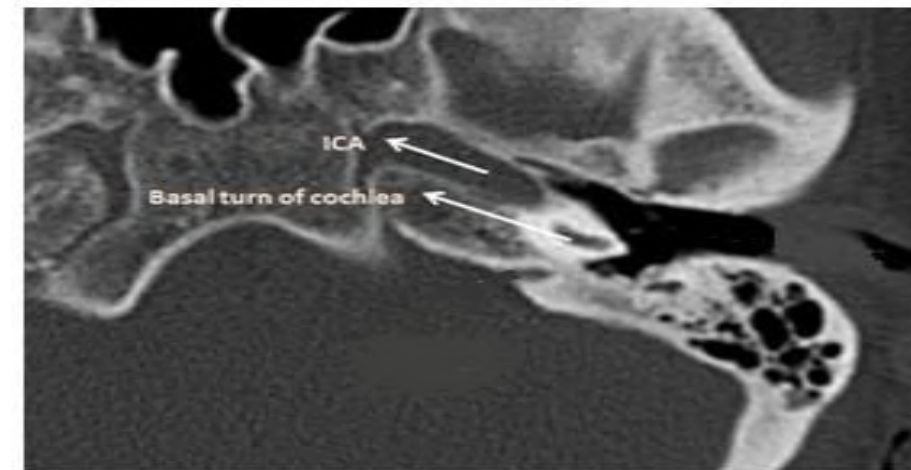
Axial CT scan of the petrous bone showing alignment between the basal turn of the cochlea and the horizontal segment of the petrous carotid artery.
